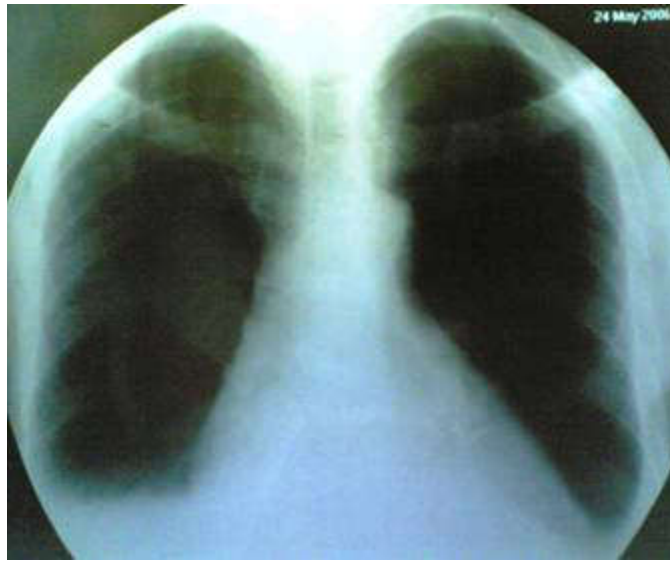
Early Postoperative Chest X-ray
